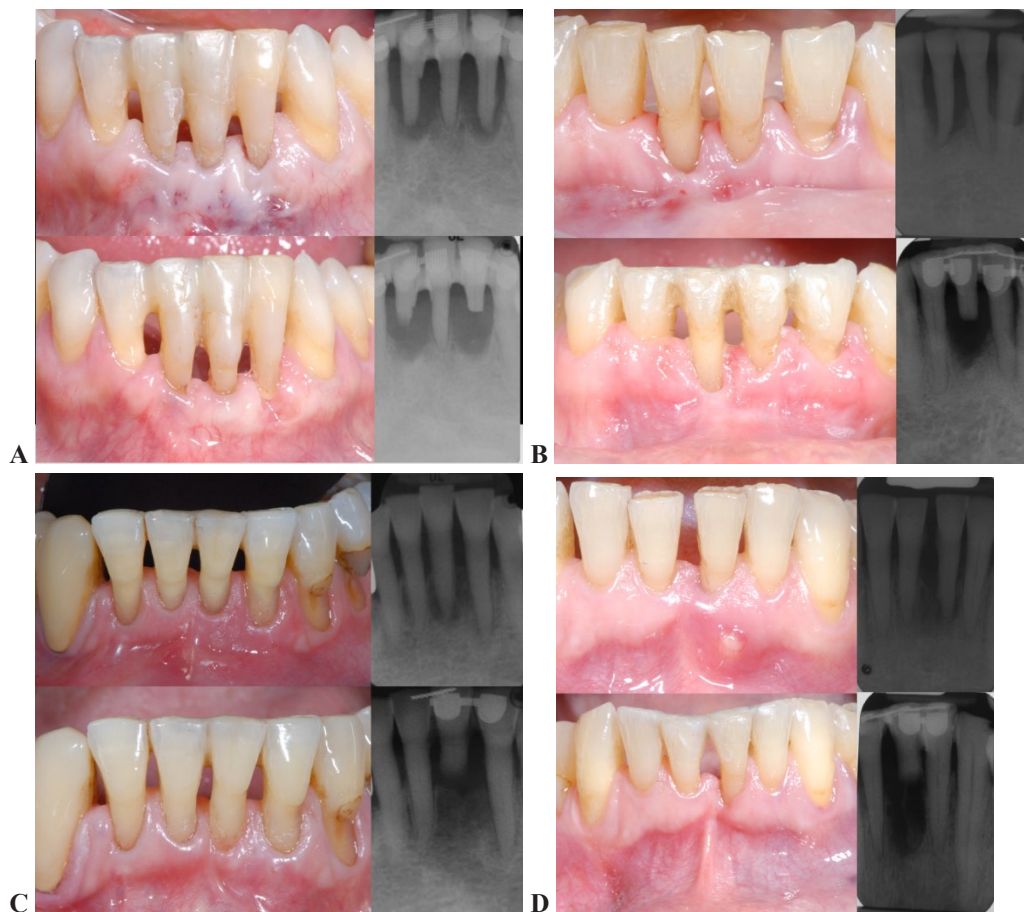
A) #PT1 Comparative clinical and radiographic pictures pre and 5 years post treatment. B) #PT2 Clinical and radiographic documentation pre and 5 years post treatment. C) #PT3 Comparative clinical and radiographic pictures pre and 5 years post treatment. D) #PT4 Clinical and radiographic documentation pre and 5 years post treatment.*
